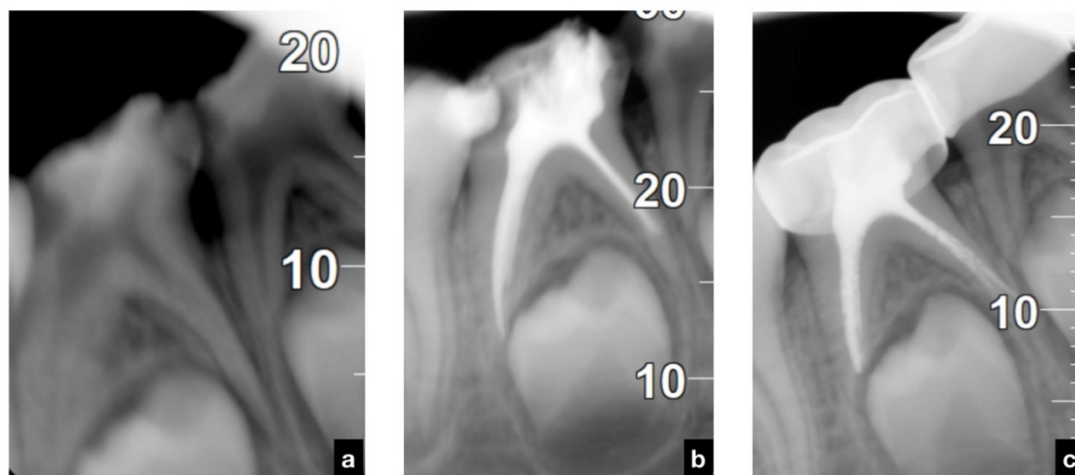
First RCT performed and primary tooth restoration. (a) Preoperative radiograph wherein the extent of caries is seen (84 disto-proximal involving enamel and dentine and 85 involving enamel, dentine, and pulp); (b) Post treatment radiograph (84 with disto-proximal GIC restoration and 85 with obturation after root canal instrumentation); (c) Placement of crowns on 84 and 85.
